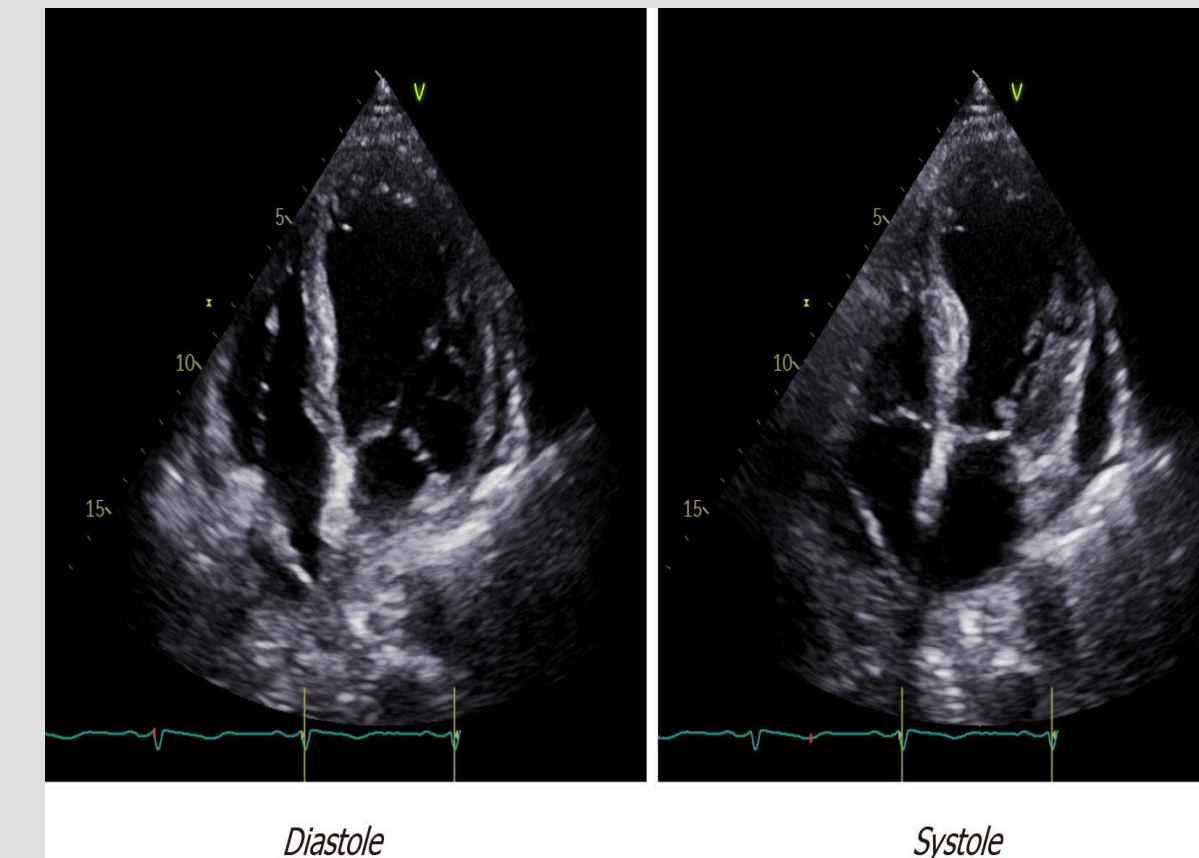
Echocardiogram demonstrating apical ballooning (9)
